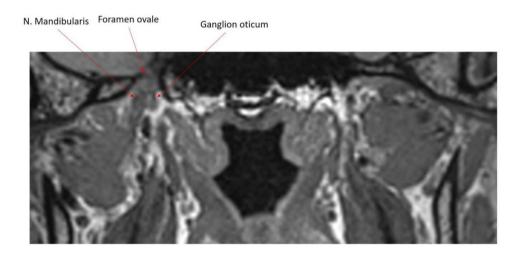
Coronal image obtained in a 3-Tesla MRI scanner. Courtesy of Prof. Erik Magnus Berntsen.
